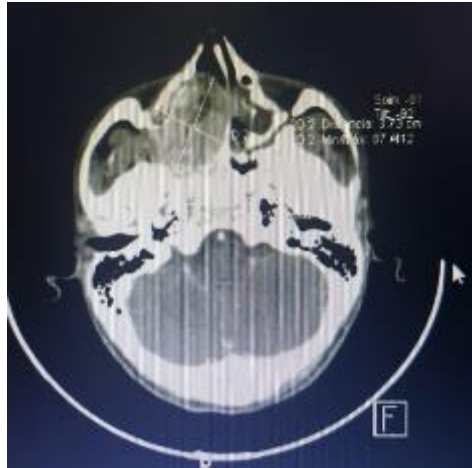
Axial slice of contrast-enhanced computed tomography showing an occupying mass in the left nasal cavity and maxillary sinus.
